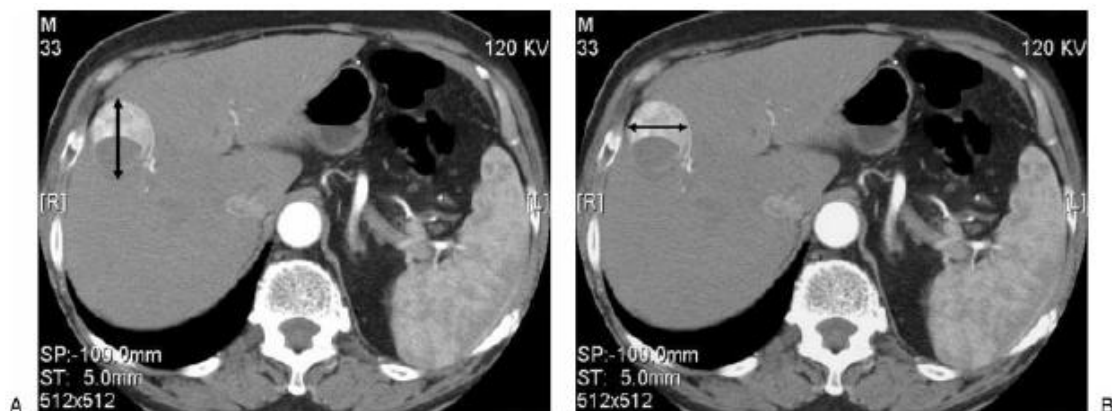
Application of mRECIST assessment for hepatocellular carcinoma (HCC). Target tumor response measurements on arterial-phase computed tomography (CT) scans. (A) Measurement of longest overall tumor diameter according to conventional RECIST, and (B) measurement of longest viable tumor diameter according to mRECIST for HCC. [4]
